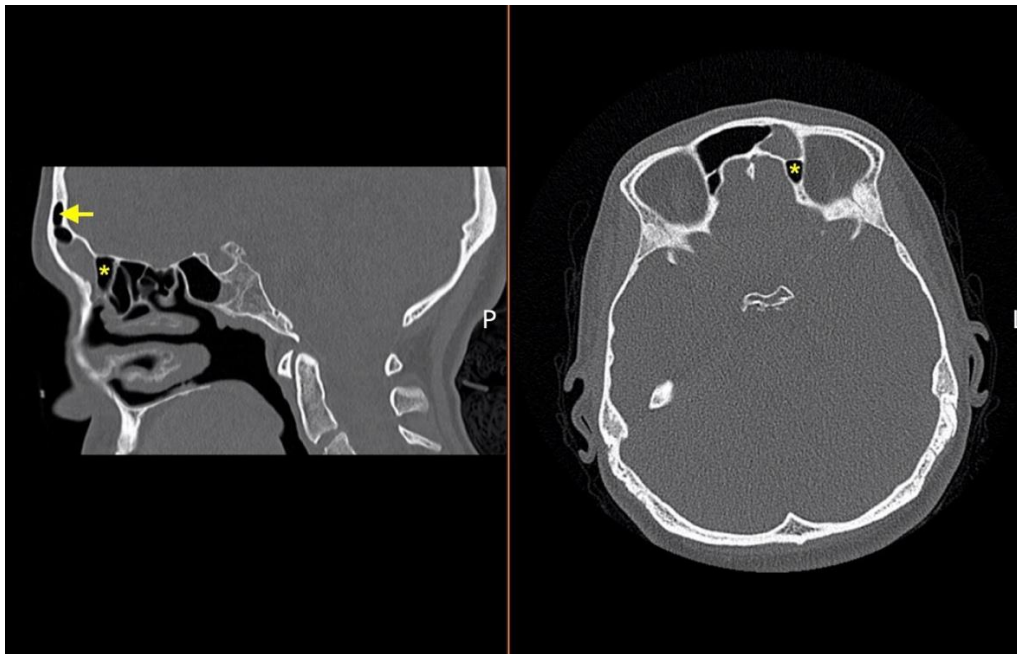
Computed tomography images of a patient with isolated frontal sinusitis on the left side. The posterior wall of the frontal sinus drainage pathway is formed by a supraorbital ethmoid cell (asterisk). Note that the right frontal sinus extends into the left side (arrow). P, posterior; L, left.
